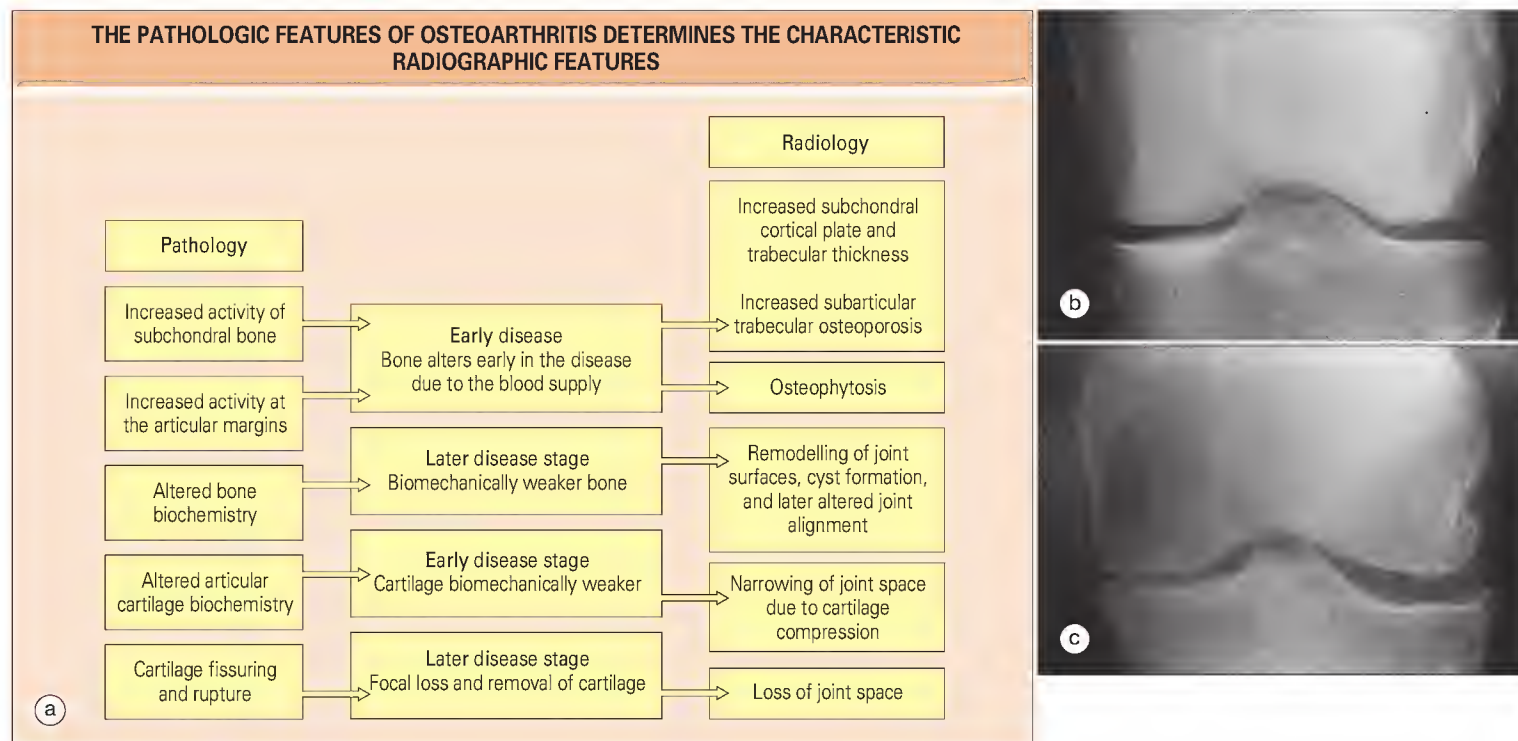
(a) Pathologic changes in osteoarthritis and the corresponding characteristic radiographic features visualized in plain radiographs of joints with early- and late-stage disease. (b) Radiograph of a healthy knee. (c) Radiograph of a knee with late disease showing most of the features listed in (a).
